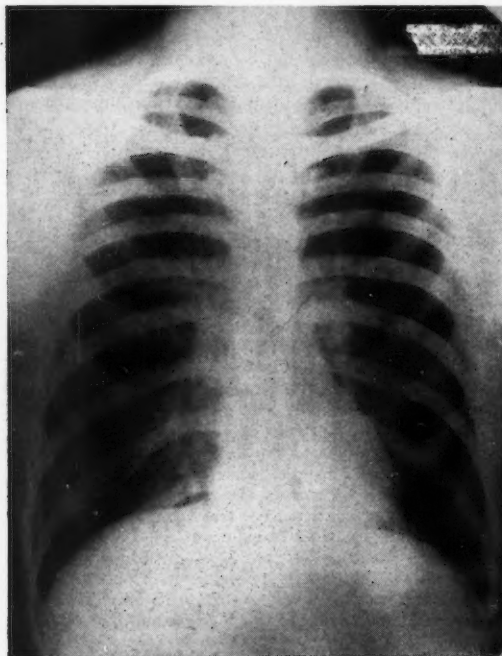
Anterior-posterior x-rays of the lungs revealing diffuse infiltration of both lung fields.
